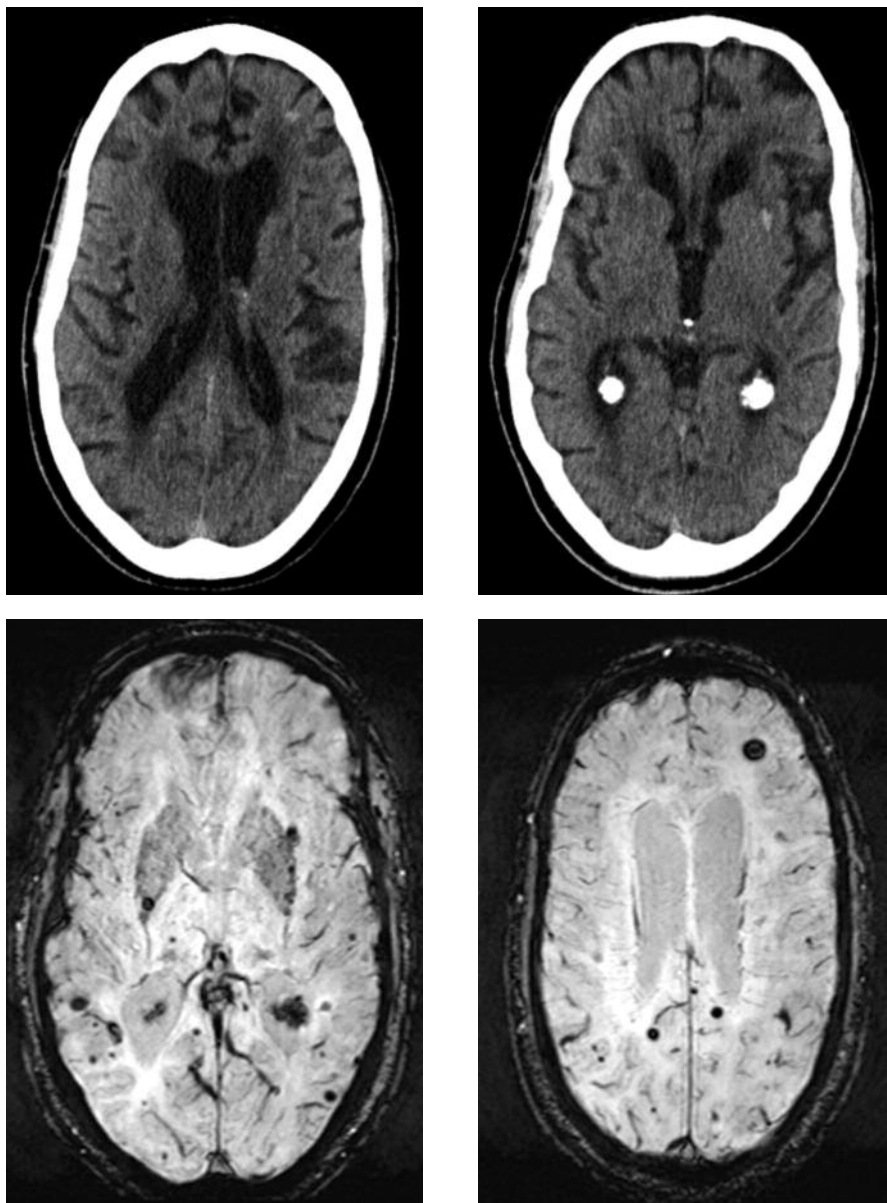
Clinical case highlighting advantages of MRI over CT: A 72-year-old male patient presented with acute onset right arm weakness and was considered for IV thrombolysis. CT (a, b) showed two small hyperdensities, which could represent small bleeds or cavernomas. Subsequent MRI (susceptibility weighted images c,d) revealed extensive cerebral microbleeds not seen on CT and probable amyloid angiopathy. The patient was not thrombolysed.
